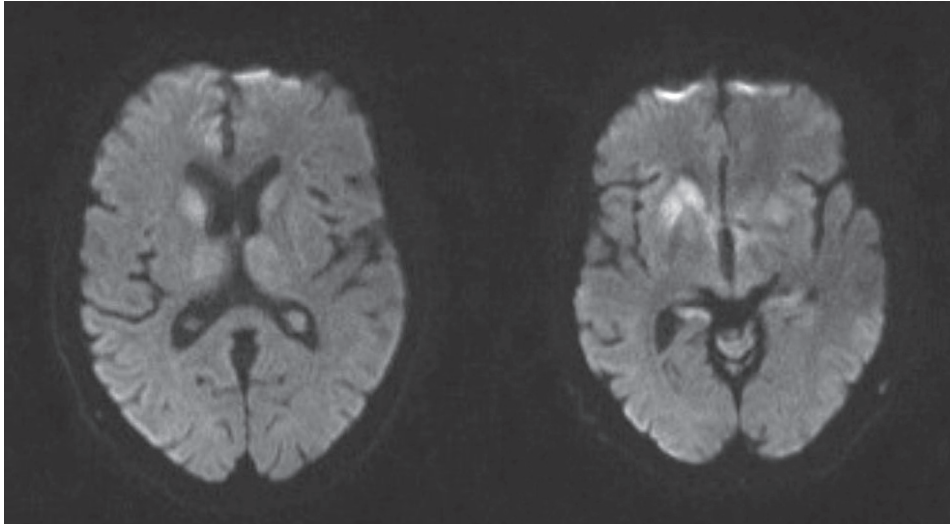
Bilateral caudate head and right putamen hyperintensity on FLAIR MRI sequences
